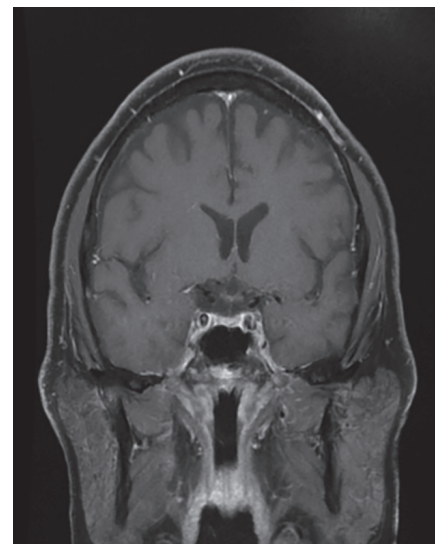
Repeat MRI showing significant improvement; after 6 remsimas infusions and while on tapering regime of prednisolone and methotrexate 10 mg.
